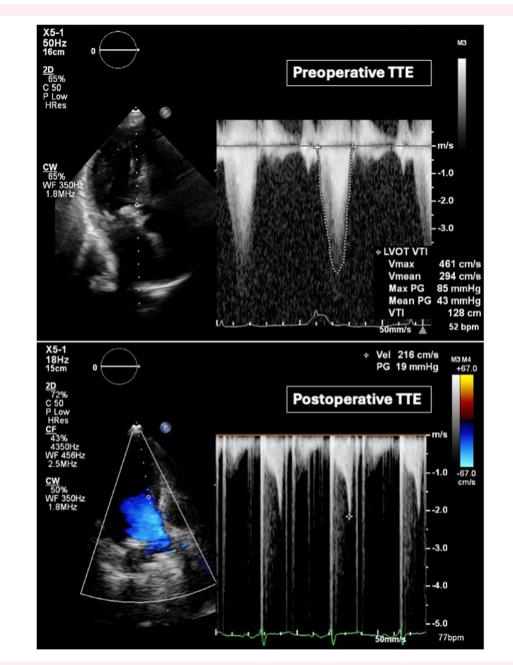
Transthoracic echocardiogram. Preoperatively, the maximum pressure gradient in the left ventricular outflow tract was 85 mmHg with the valsalva manoeuvre, but it improved to 15 mmHg post-operatively.
